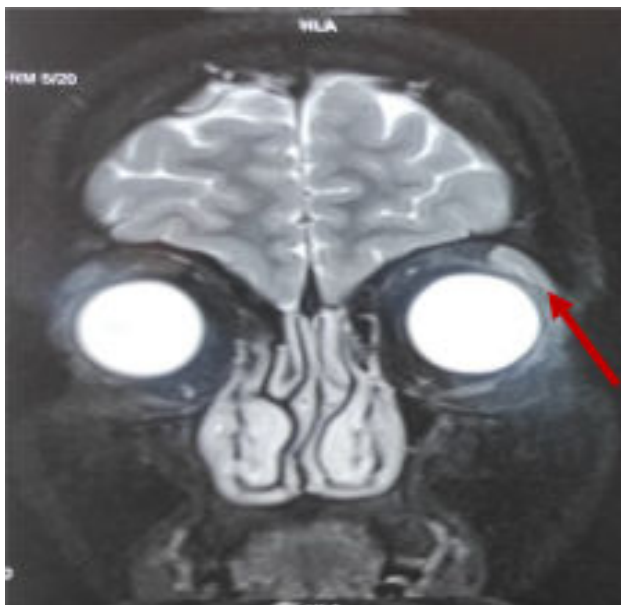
MRI orbit (coronal view) showing enlargement and enhancement of left lacrimal gland
